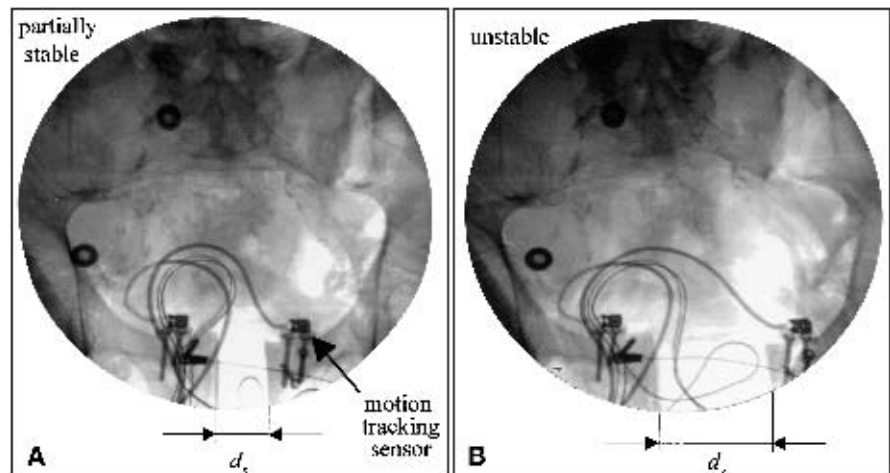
Anteroposterior fluoroscopic radiographs of the partially stable (a) and unstable (b) pelvic fracture model, obtained after recoil of the pelvic ring.
